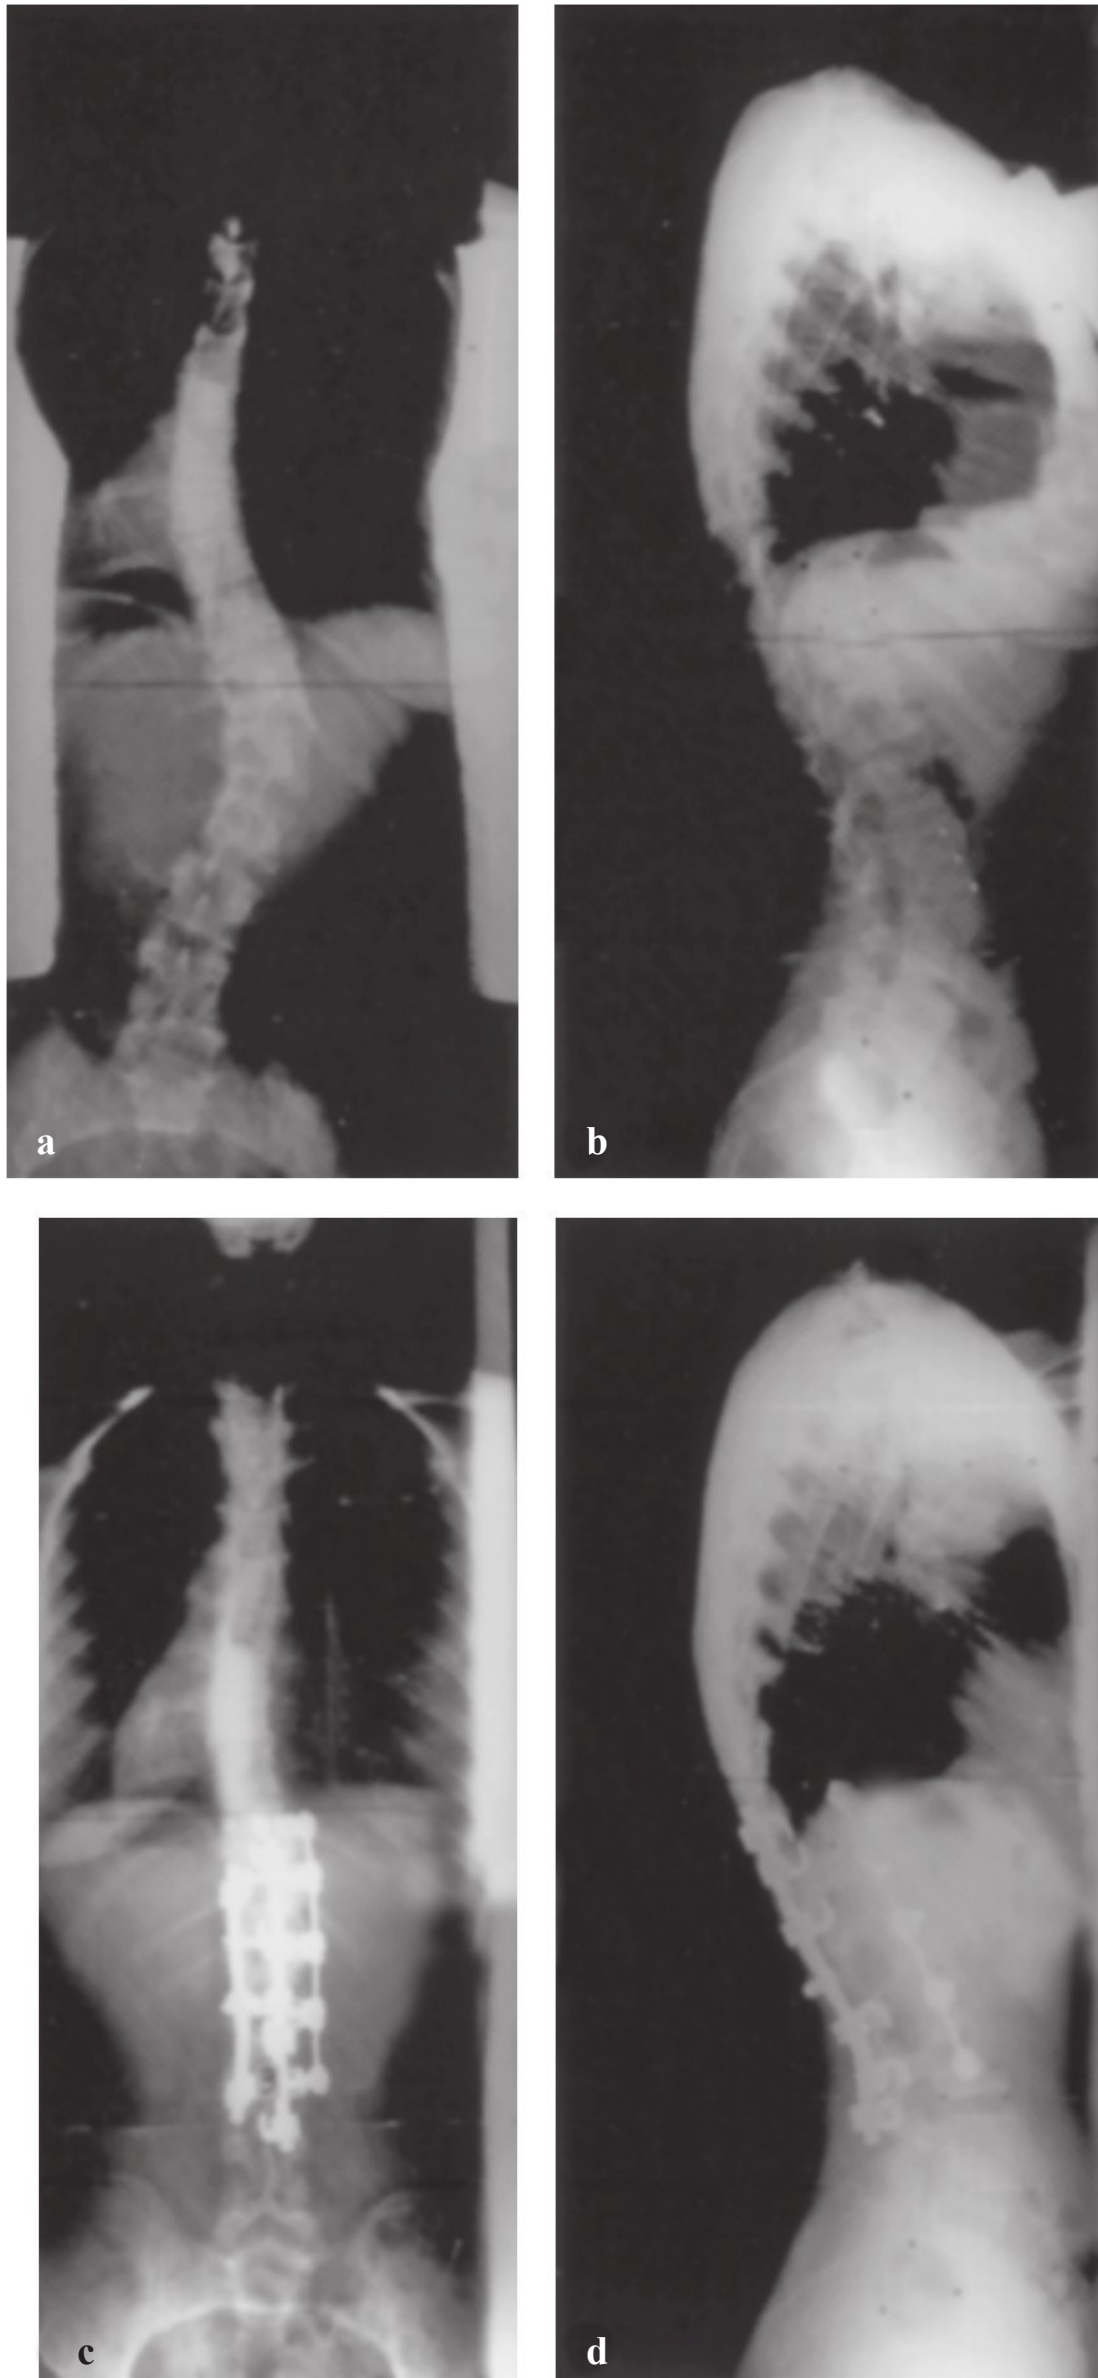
A 17-year-old girl with adolescent idiopathic scoliosis. (a) Anteroposterior radiograph demonstrating a 49° right thoracolumbar curve with maintenance of the overall coronal balance. (b) Lateral radiograph demonstrates relatively preserved sagittal alignment. Postoperative (c) anteroposterior and (d) lateral radiographs with an anteroposterior release and fusion.
